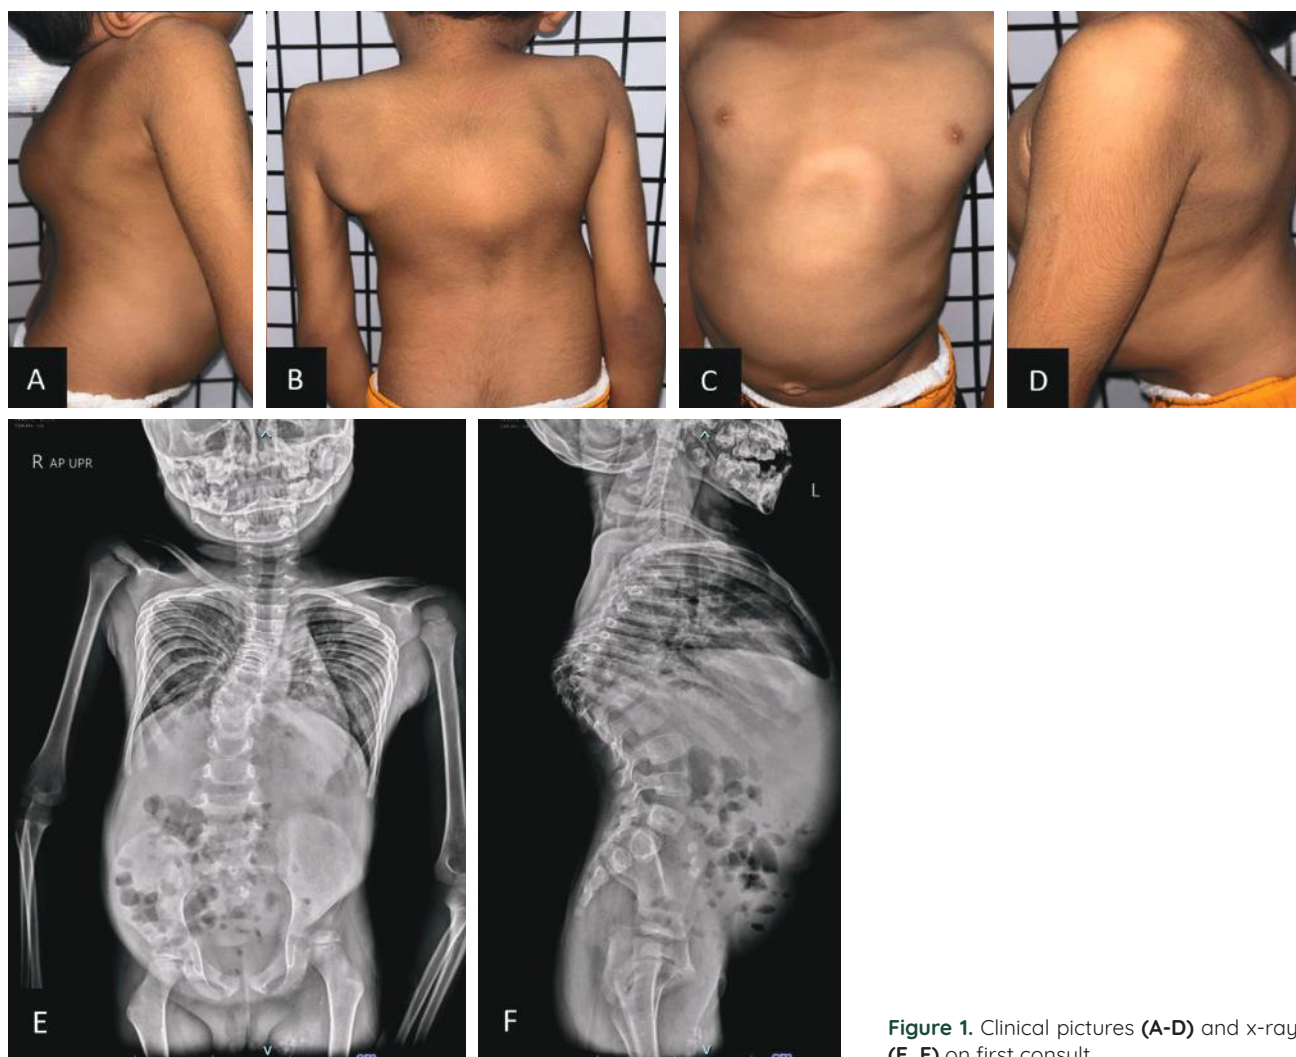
Clinical pictures (A-D) and x-rays (E, F) on first consult.
